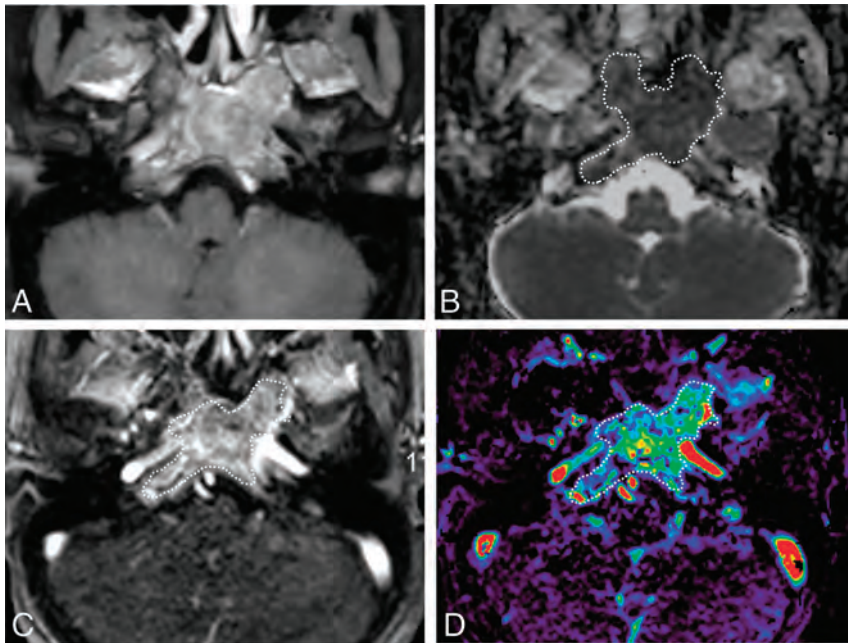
A 39-year-old woman with a metastatic breast cancer lesion in the clivus. *A*, Axial fat-saturated postcontrast T1-weighted image shows a heterogeneously enhancing mass in the clivus. *B*, An ROI was placed on the ADC map, and the nADCmean was 0.97. *C*, An ROI was placed on the permeability map, and V_p , K^{trans} , and V_e were calculated. *D*, V_p showed 0.23.
